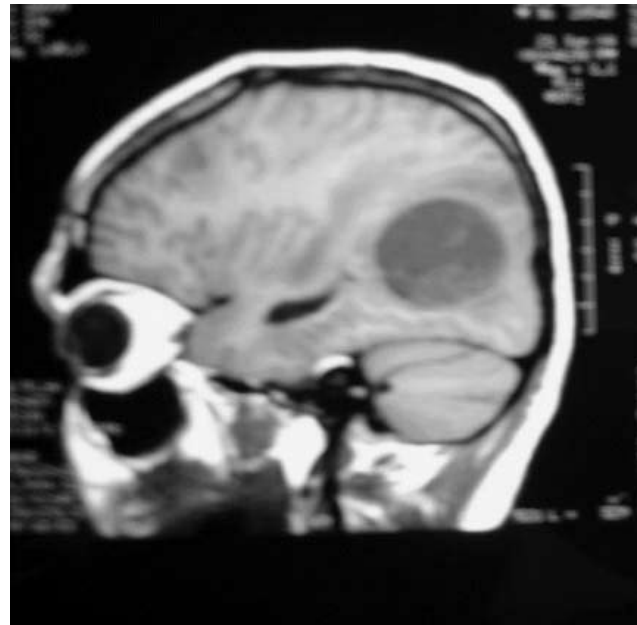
MRI showing Tuberculoma Brain
